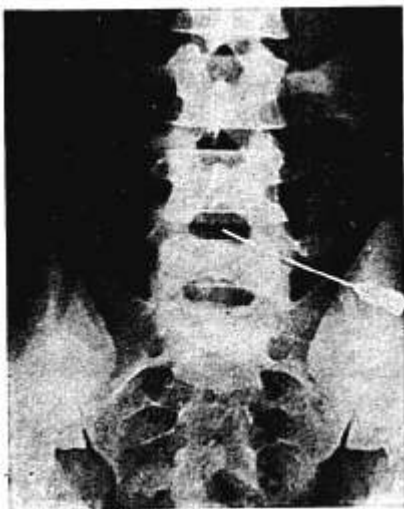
Anteroposterior x-ray picture of lumbosacral region with spinal needle in place at L4-L5 interspace.
